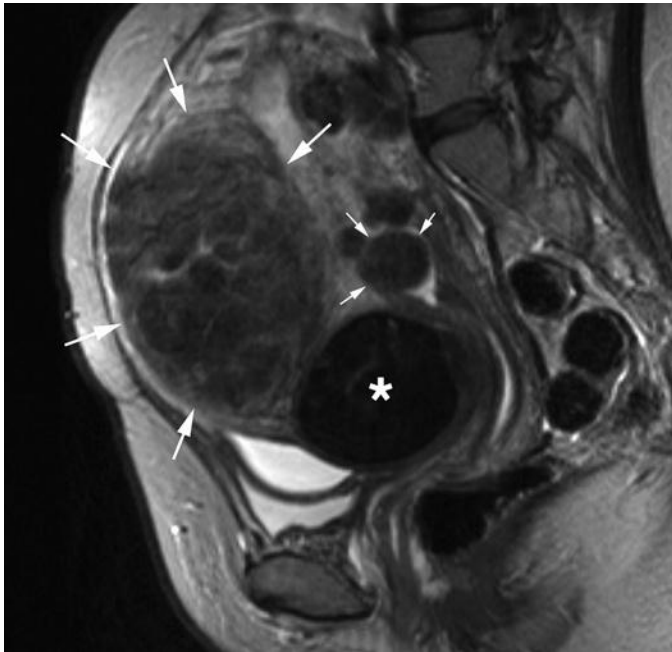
Sagittal T2-weighted (T2W) magnetic resonance image demonstrating various different but common appearances of leiomyomas: small submucosal leiomyoma impressing the endometrial canal with typical low T2W signal (*small arrows*), large anterior intramural leiomyoma (*large arrows*) with internal edema and degeneration (*white areas*), and anterior lower uterine segment leiomyoma (*asterisk*) with extremely low T2W signal consistent with internal blood products/hemosiderin from “red degeneration.”
